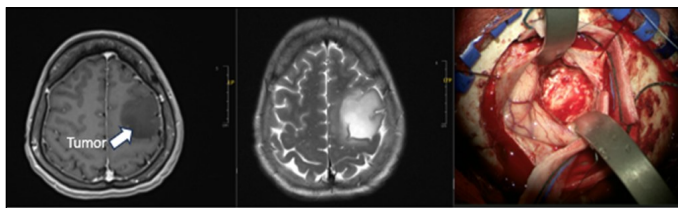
(from left to right): Minimally enhanced left frontal tumour on axial T1-weighted image with gadolinium and hyperintense on T2-weighted image. Intraoperative picture showing tumour debulking.
